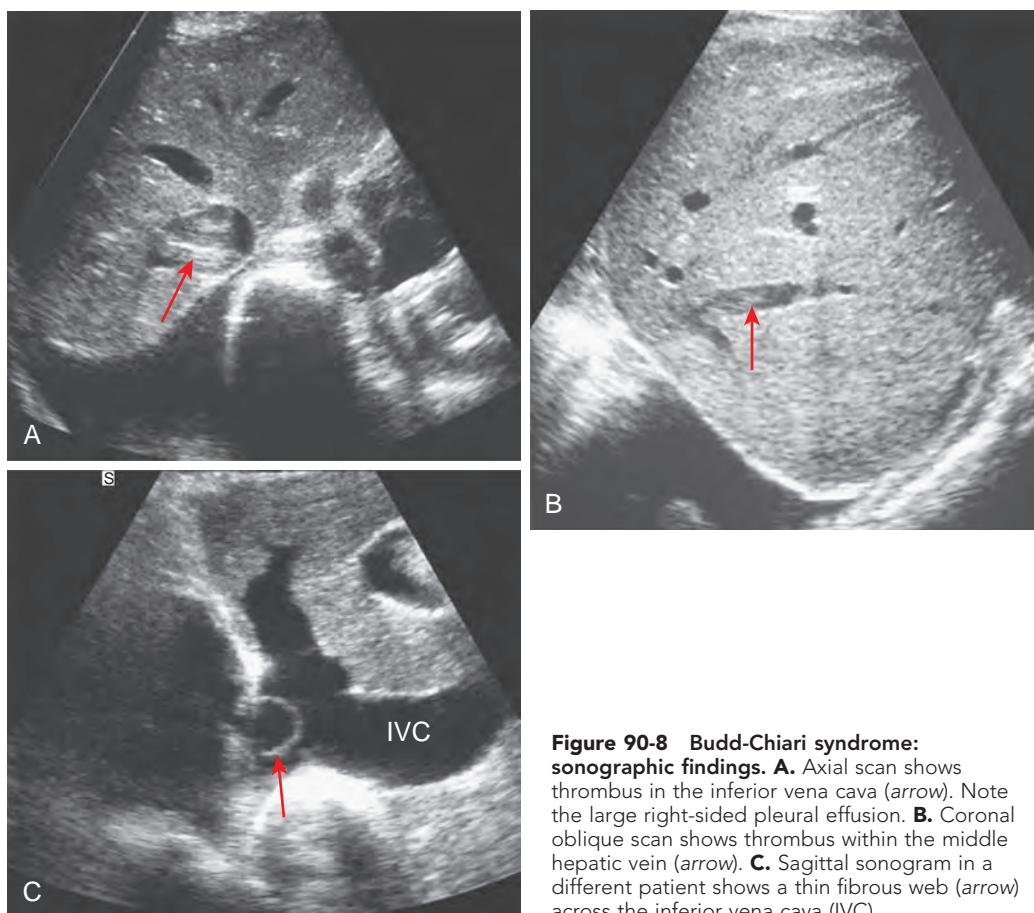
Budd-Chiari syndrome: sonographic findings. A. Axial scan shows thrombus in the inferior vena cava (arrow). Note the large right-sided pleural effusion. B. Coronal oblique scan shows thrombus within the middle hepatic vein (arrow). C. Sagittal sonogram in a different patient shows a thin fibrous web (arrow) across the inferior vena cava (IVC).
